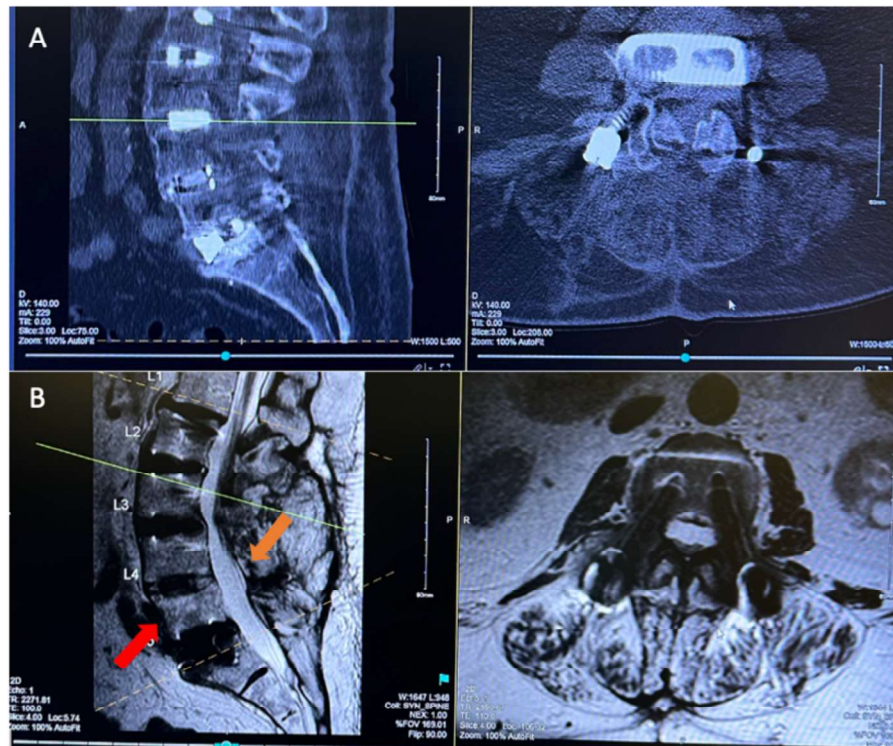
(A) Sagittal and Axial CT and (B) Sagittal and Axial MRI of L1-L5 with instrumentation present in all lumbar levels post 3rd and 4th back surgery.
